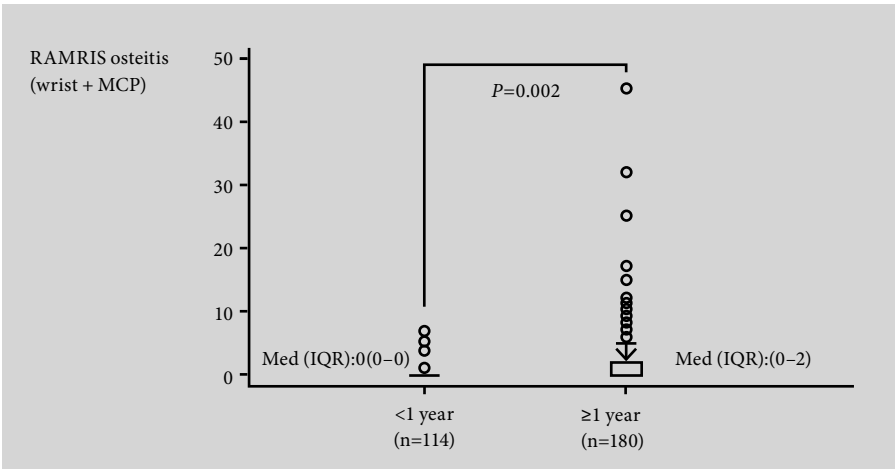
Magnetic resonance imaging osteitis in patients with early rheumatoid arthritis and late rheumatoid arthritis in clinical remission or low disease activity state. IQR, interquartile range; MCP, metacarpophalangeal joint; Med, median; RAMRIS, rheumatoid arthritis MRI scoring system. Reproduced with Gandjbakhch et al [34] ©The Journal of Rheumatology Publishing Company.
